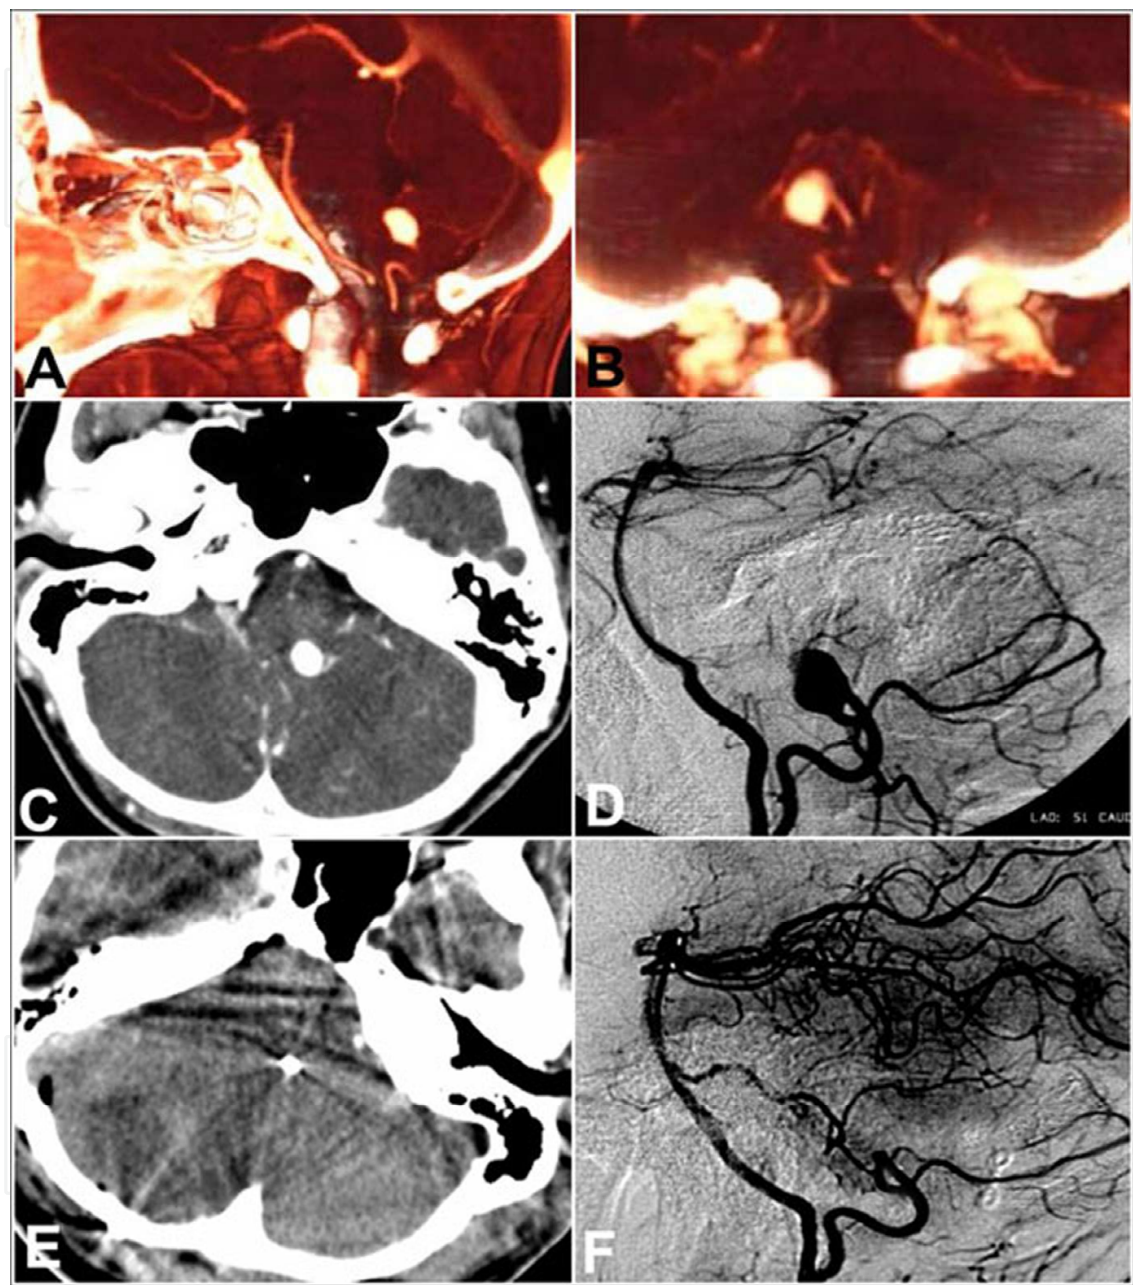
Preoperative angio-CT sagittal and coronal reconstructions (A,B), preoperative angio-CT scan (C), preoperative angiography (D), postoperative CT scan (E) and postoperative angiography (F) of a large, wide based, aneurysm of the distal portion of the right PICA, deeply embedded into the left lateral recess of the fourth ventricle, which was approached through a suboccipital telovelar approach.
